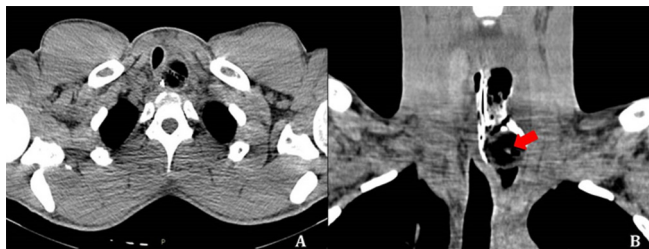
Appearance of the impacted foreign body at preoperative CT scan on axial (A) and coronal (B) plane at D3 vertebral level. The arrow shows the central hole of the sphere bead.
